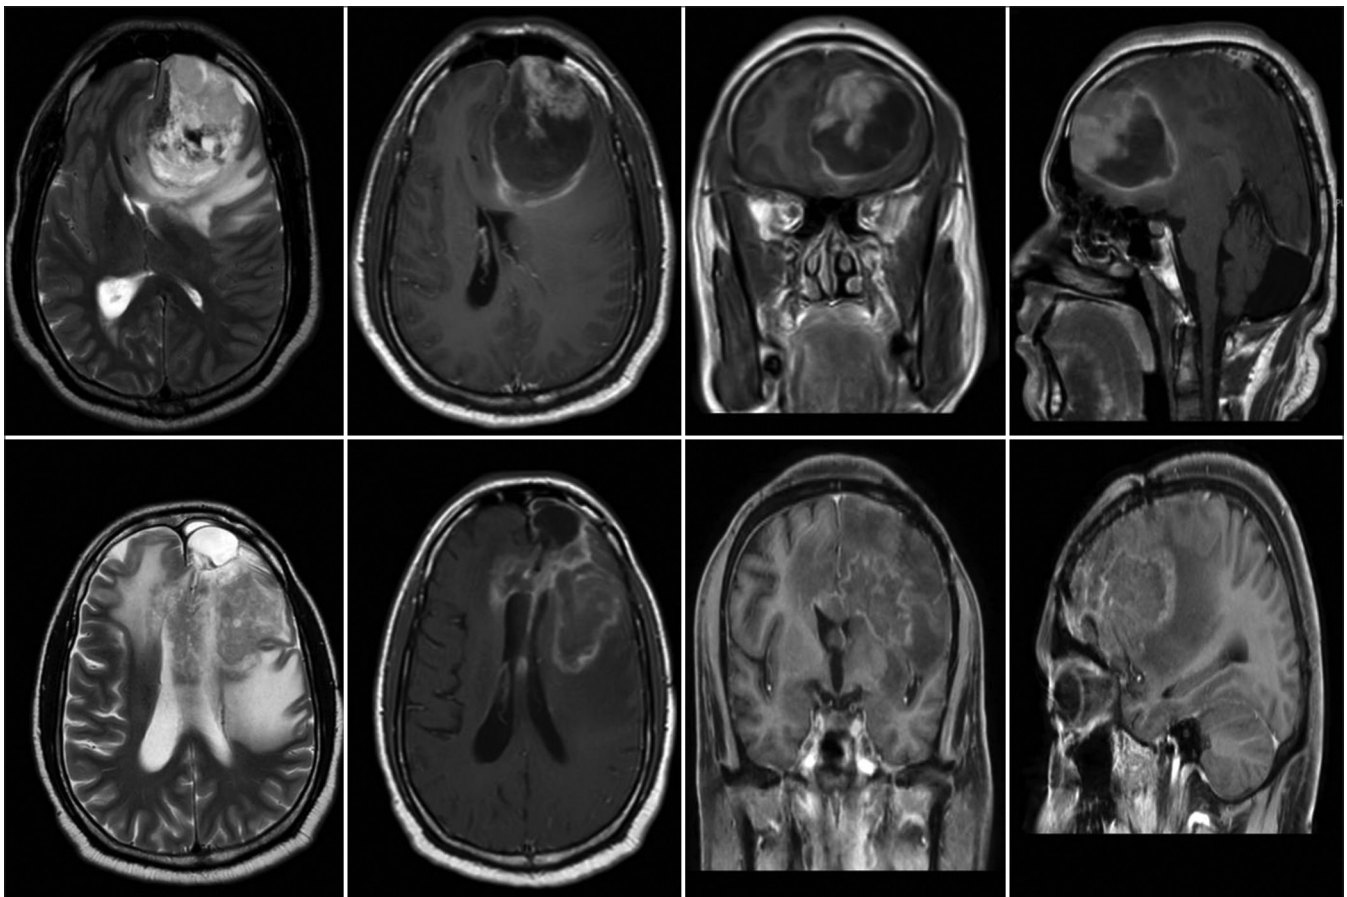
MRI imaging with gadolinium contrast depicting solid cystic tumor with dural attachment at convexity. (Top Row) Follow-up MRI at 6 months depicting tumor progression (Bottom Row).
